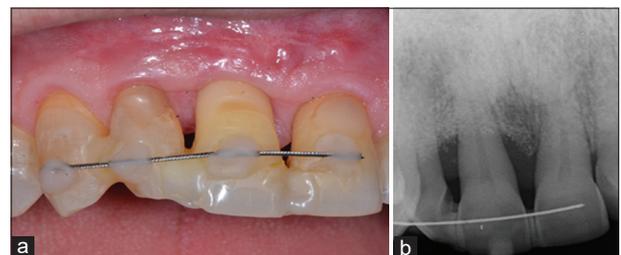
(a) 4 months after treatment clinical view (After) and (b) periapical radiography
